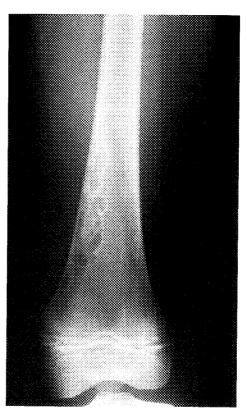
Fibrous cortical defect. An 8-year-old boy was asymptomatic until he sprained his knee while playing. An anteroposterior radiograph shows a large eccentric defect well marginated in the distal femur.
